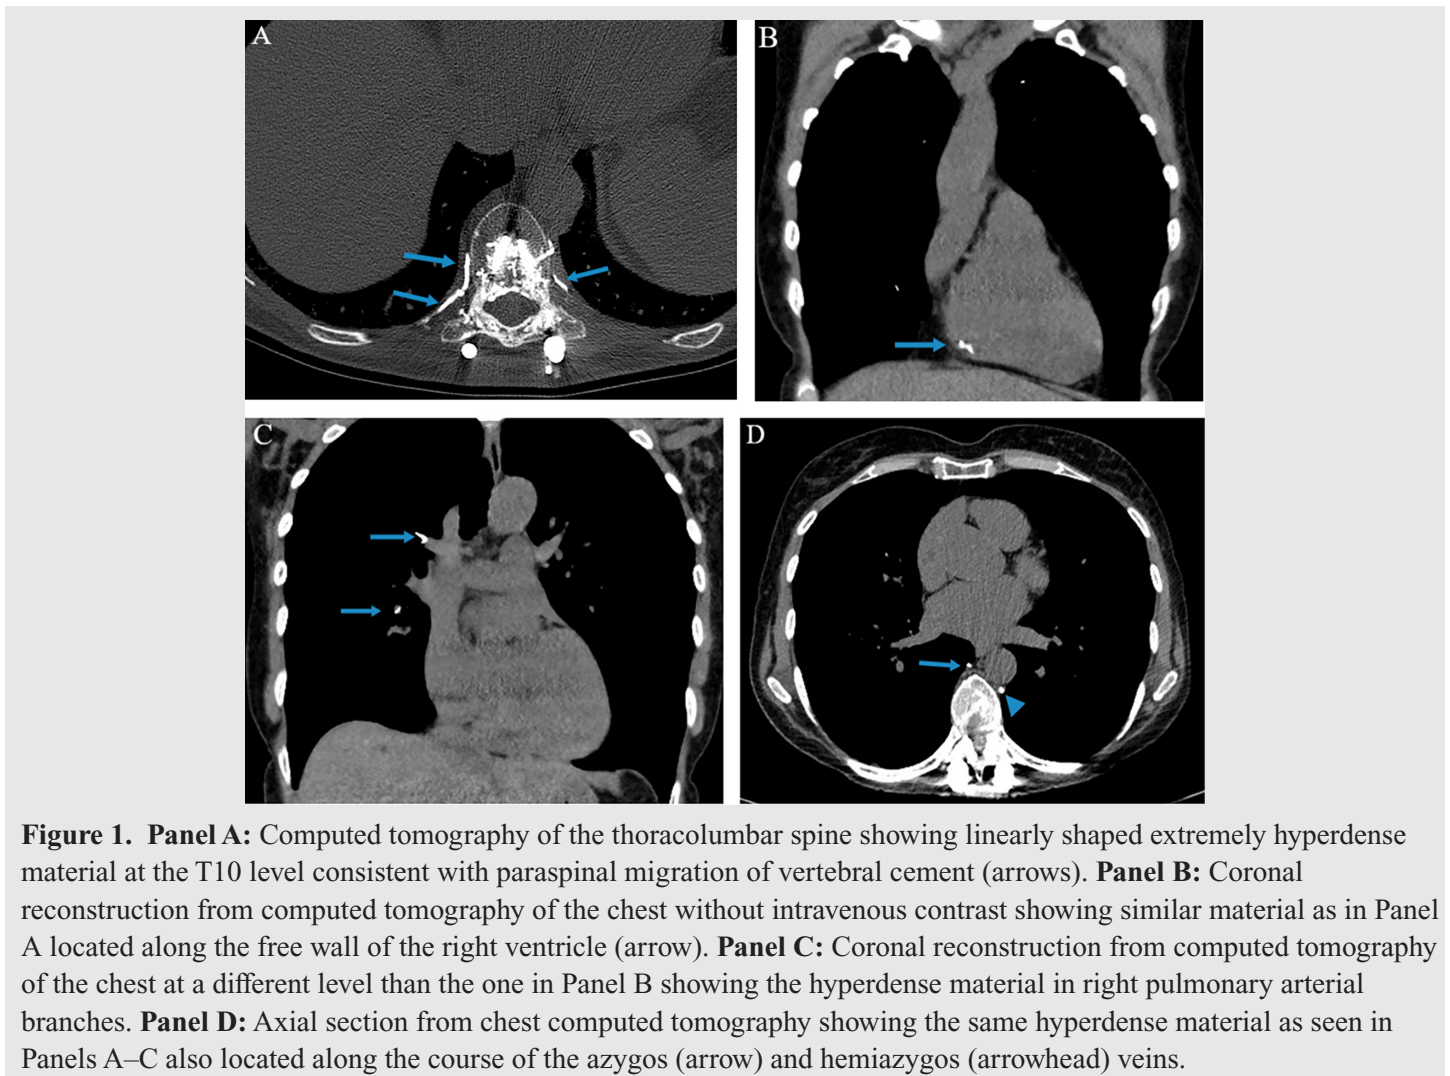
Panel A: Computed tomography of the thoracolumbar spine showing linearly shaped extremely hyperdense material at the T10 level consistent with paraspinal migration of vertebral cement (arrows). Panel B: Coronal reconstruction from computed tomography of the chest without intravenous contrast showing similar material as in Panel A located along the free wall of the right ventricle (arrow). Panel C: Coronal reconstruction from computed tomography of the chest at a different level than the one in Panel B showing the hyperdense material in right pulmonary arterial branches. Panel D: Axial section from chest computed tomography showing the same hyperdense material as seen in Panels A–C also located along the course of the azygos (arrow) and hemiazygos (arrowhead) veins.
